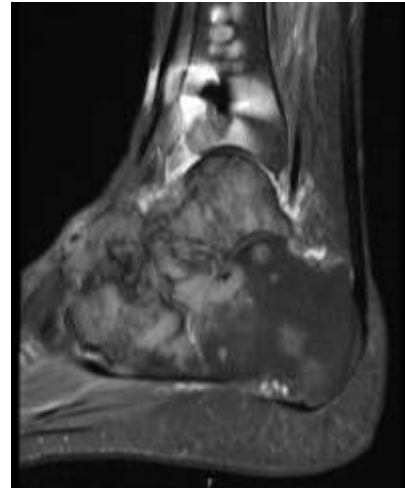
Magnetic resonance imaging shows evidence of bone signal alteration at the distal level of the distal tibia and fibula, involving the entire talus, the anterior process of the calcaneus, and the tarsal bones.
